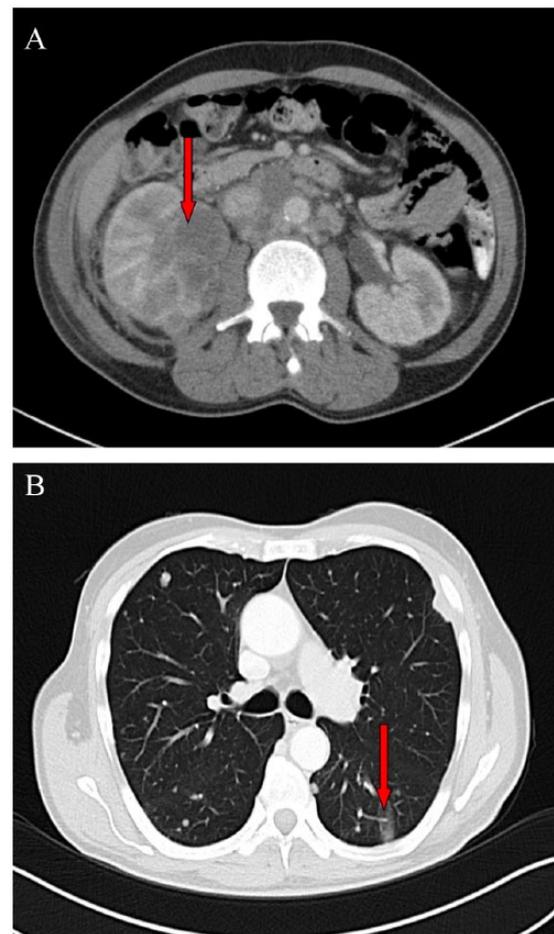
Computed tomography (CT) of (A) abdomen and (B) thorax at the time of diagnosis. CT of patient 1 showed (A) a large right-sided renal tumor 7.5 cm \times 5 cm \times 5 cm in the kidneys upper and middle parts (see arrow) and (B) bilateral multiple rounded suspect metastases in the lungs, up to 2.5 cm in diameter (see arrow).
